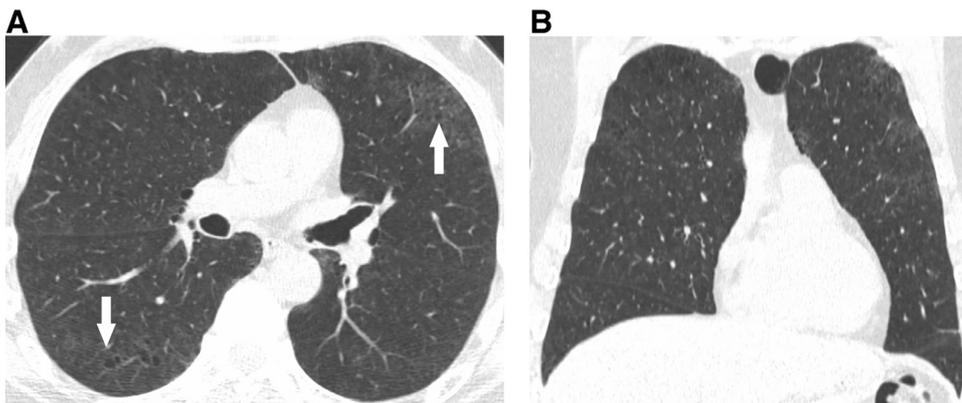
A 52-year-old male smoker with mild desquamative interstitial pneumonia. Axial (A) and coronal reformatted (B) CT images show patchy ground-glass opacity predominantly in the mid and upper lungs. Several small cystic spaces (arrows) are located within areas of ground-glass opacity. Mild paraseptal emphysema is also present.
